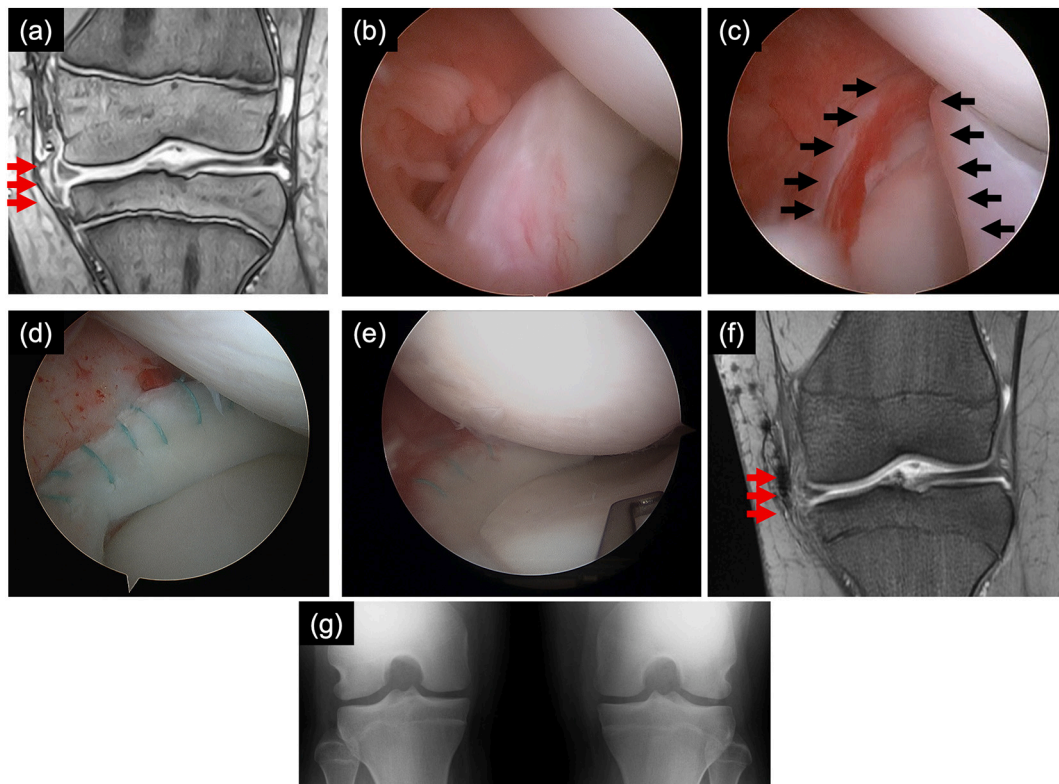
(a) Preoperative MRI; (b)/(c) arthroscopic finding: the meniscus is easily displaced by probing (black arrows) (d) postoperative arthroscopic finding; (e) second-look arthroscopic finding at six months; (f) postoperative MRI at one year: the tear site is completely healed without any abnormal high intensity area (red arrows); (g) postoperative radiograph at two years.
